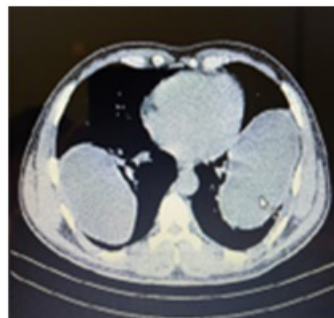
Show CT-scn of chest with billateral cystic mass of two lung.
